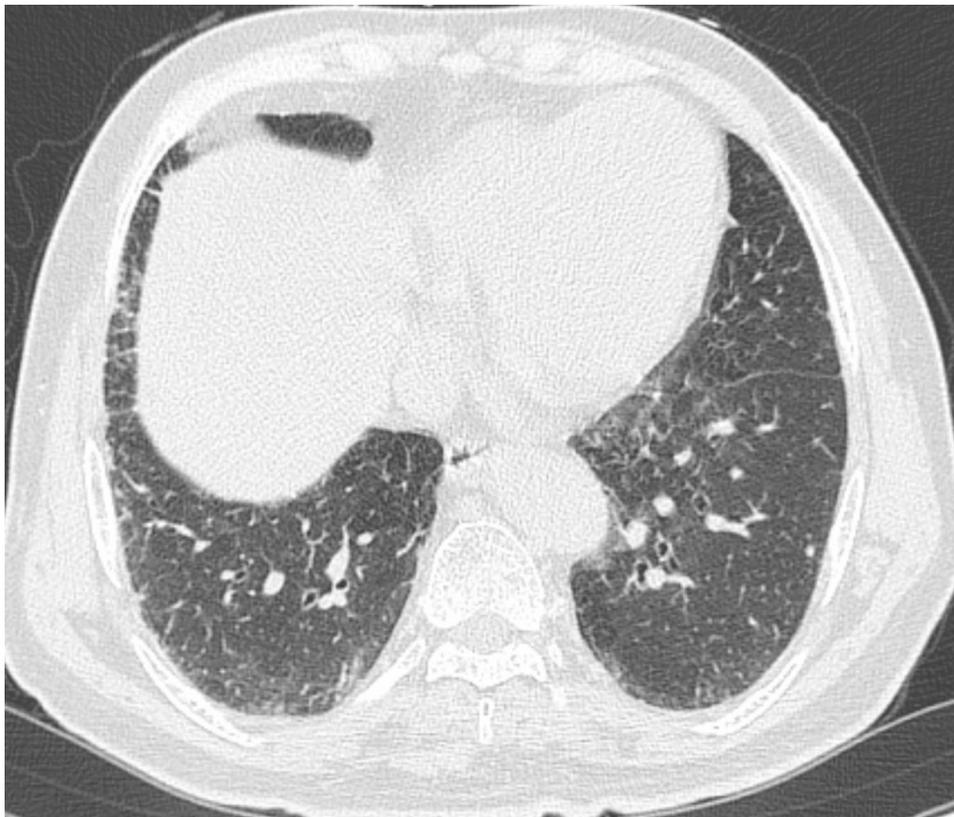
Representatives of CT images of indeterminate for UIP patterns observed in a 80-year-old never-smoker man
